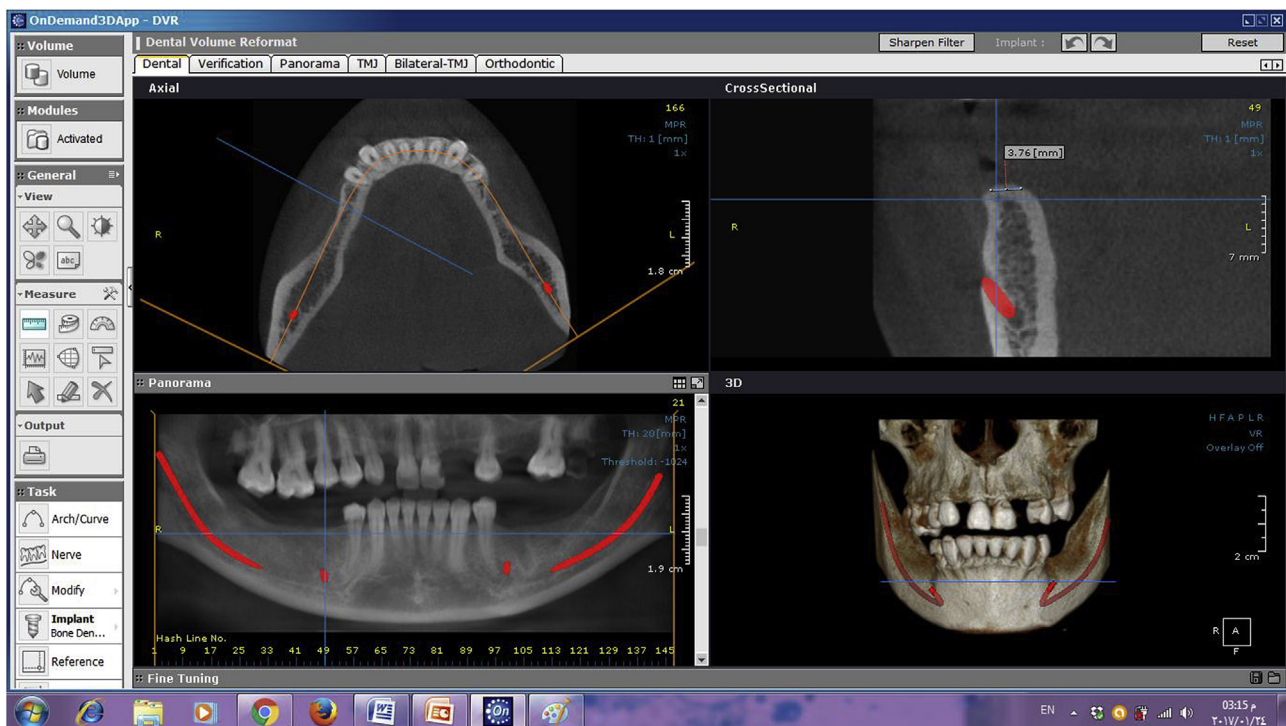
Pre-operative CBCT at right mandibular second premolar. (Bone width = 3.76 mm, Bone density = 1059.27HU) and right mandibular second molar. (Bone width = 3.58 mm, Bone density = 771.31HU).
